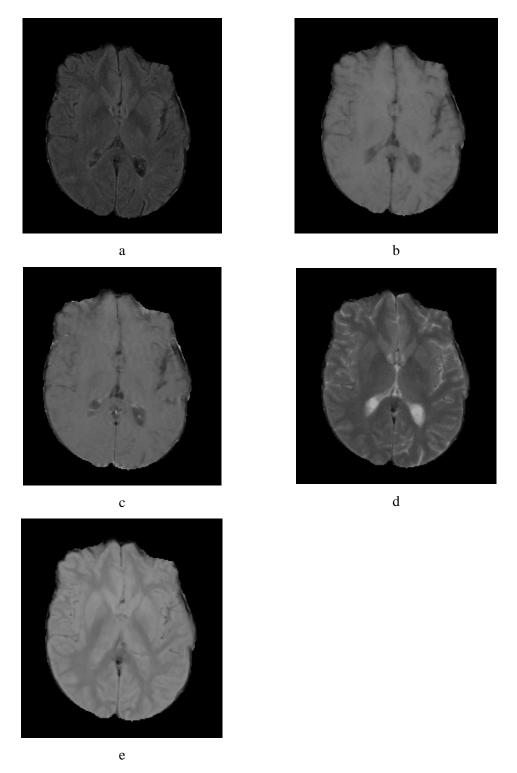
Example of C-MRI images for normal brain: a) FLAIR, b) T1-weighted, c) T2-weighted, d) T1-contrast, and e) PD.
